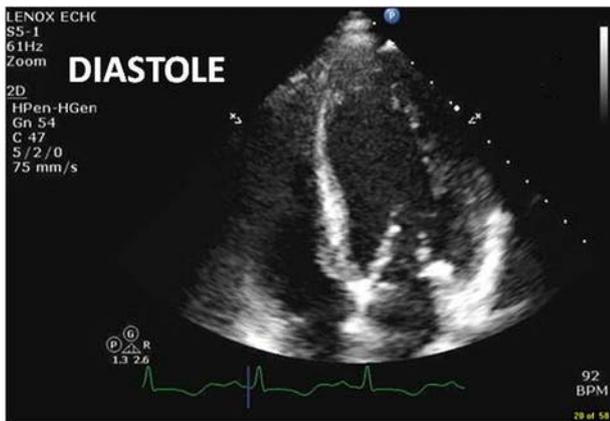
Echocardiogram showing the left ventricle during diastole with normal relaxation.
